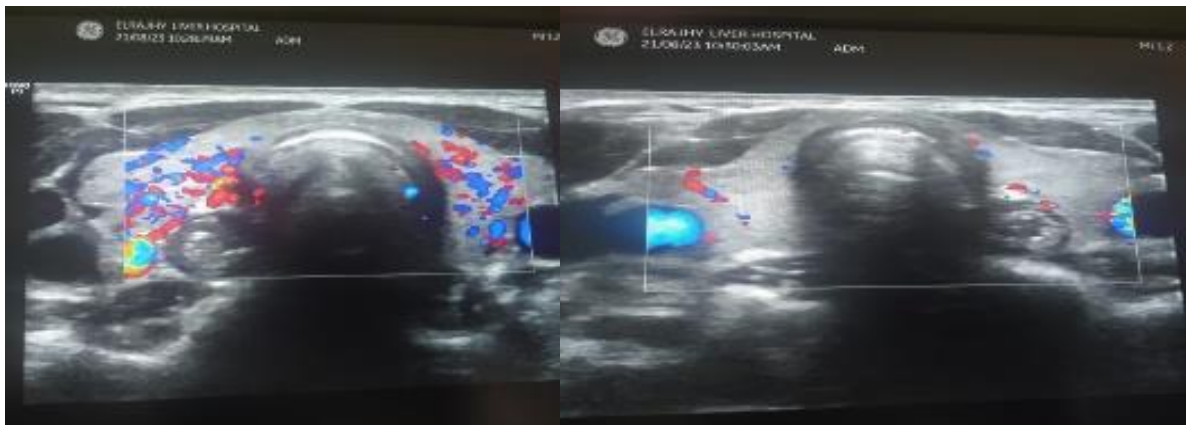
Normal thyroid ultrasound with color Doppler in UC patient with Graves’ disease three patient (4.0%) with UC have nodules in there ultrasound : first patient get left lobe nodule 1.5 cm×2cm , second patient get right lobe nodule 3cm×2cm and the third patient get 2 nodules in left and 1 nodule in right lobe.
